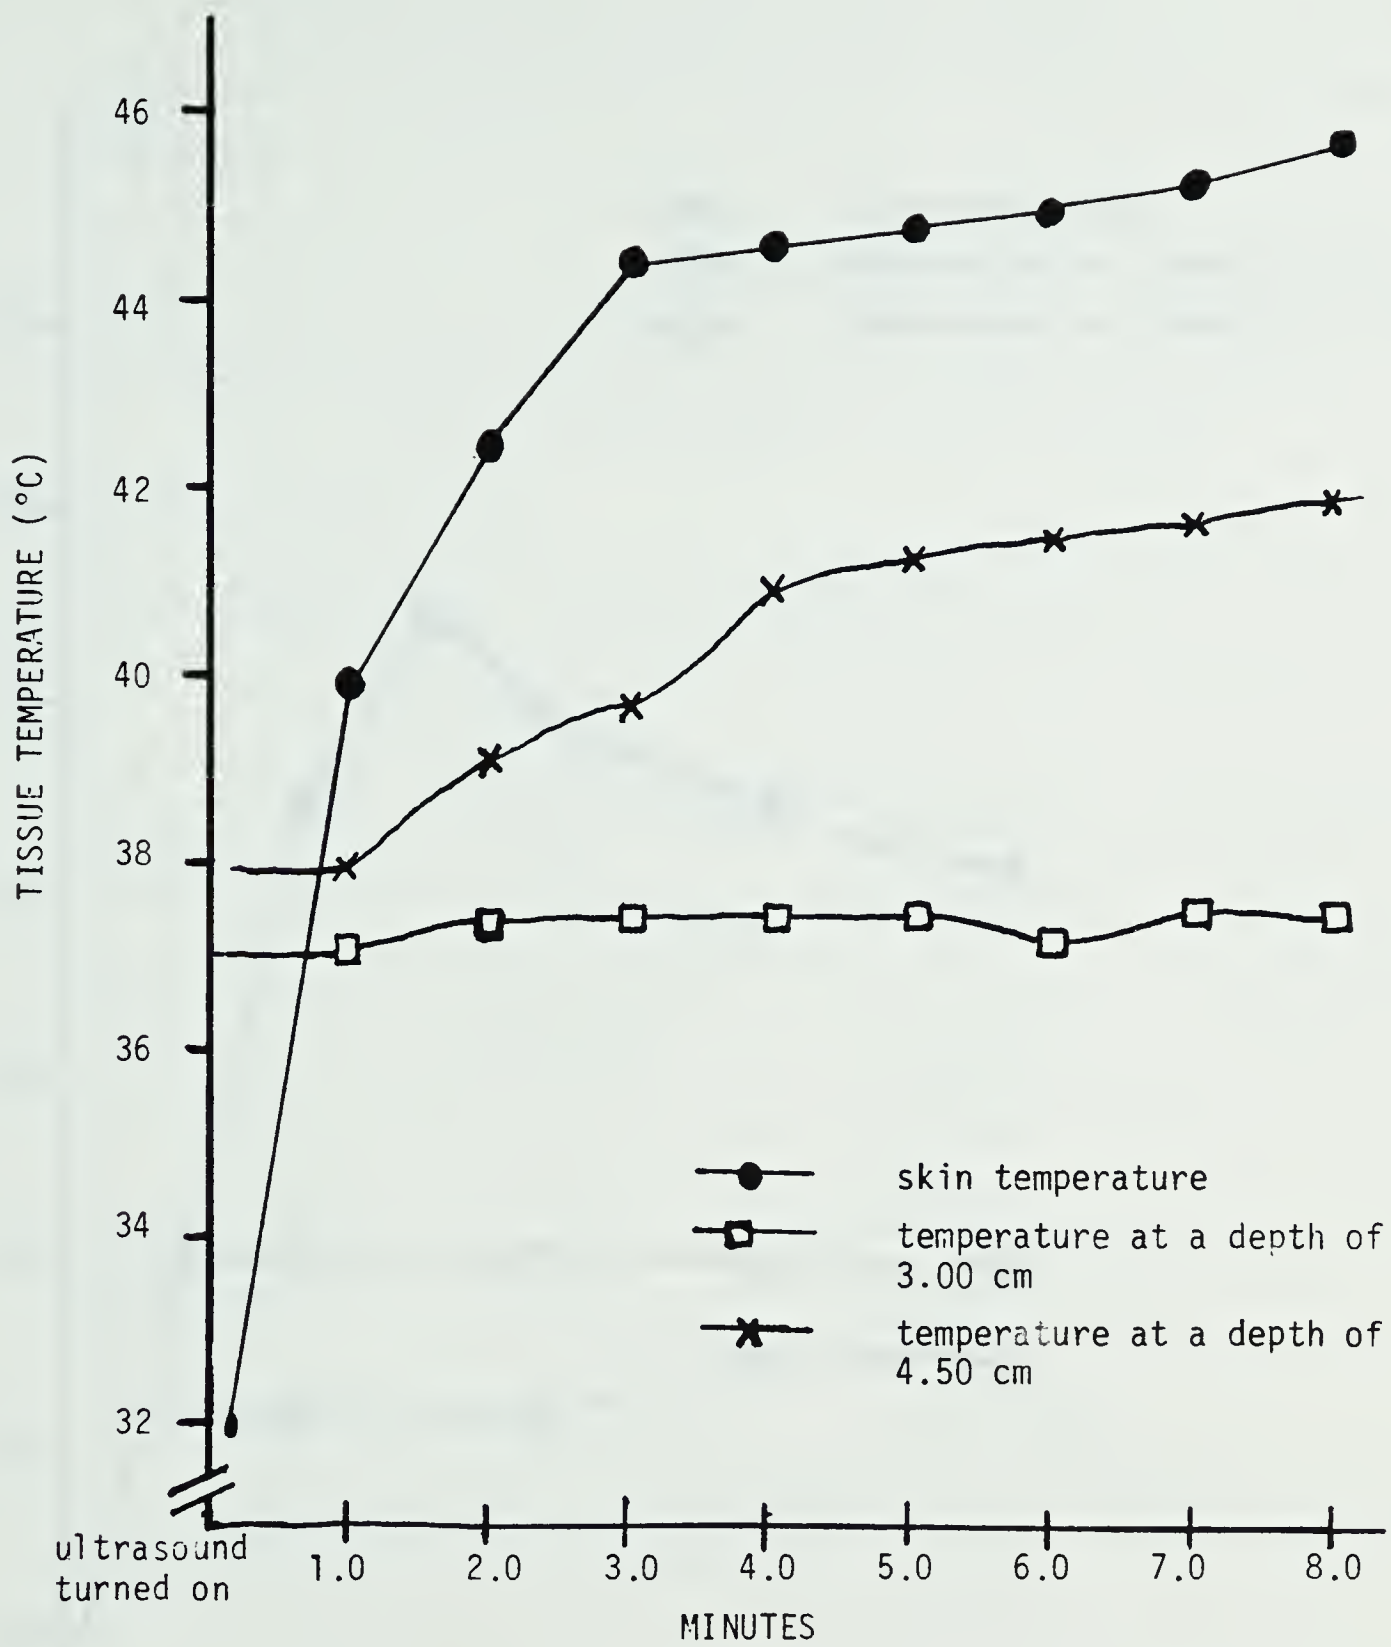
TISSUE TEMPERATURE CHANGE AT SKIN SURFACE 3.00 cm AND 4.5 cm DURING THE APPLICATION OF ULTRASOUND (INTENSITY: 1 watt/cm²; MINERAL OIL COUPLE AT 24°C)
